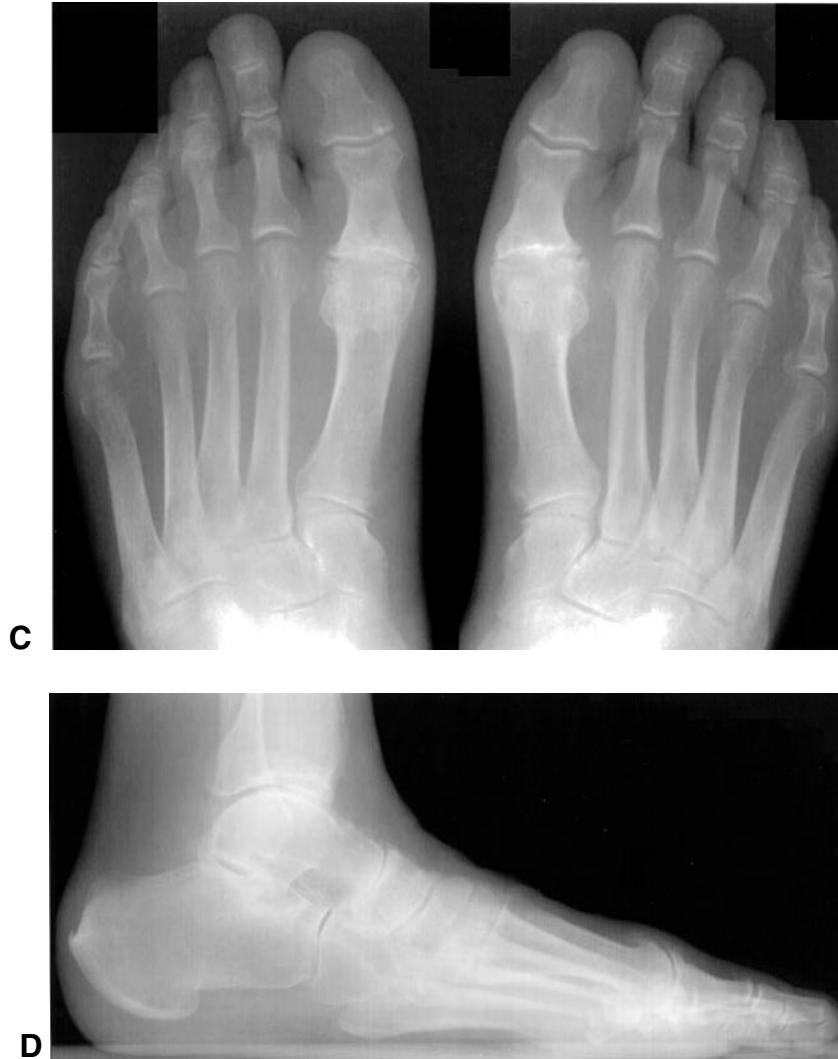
Radiographs of extremities of a 57-year-old man with Whipple's disease. A and B, hands. C and D, feet.
